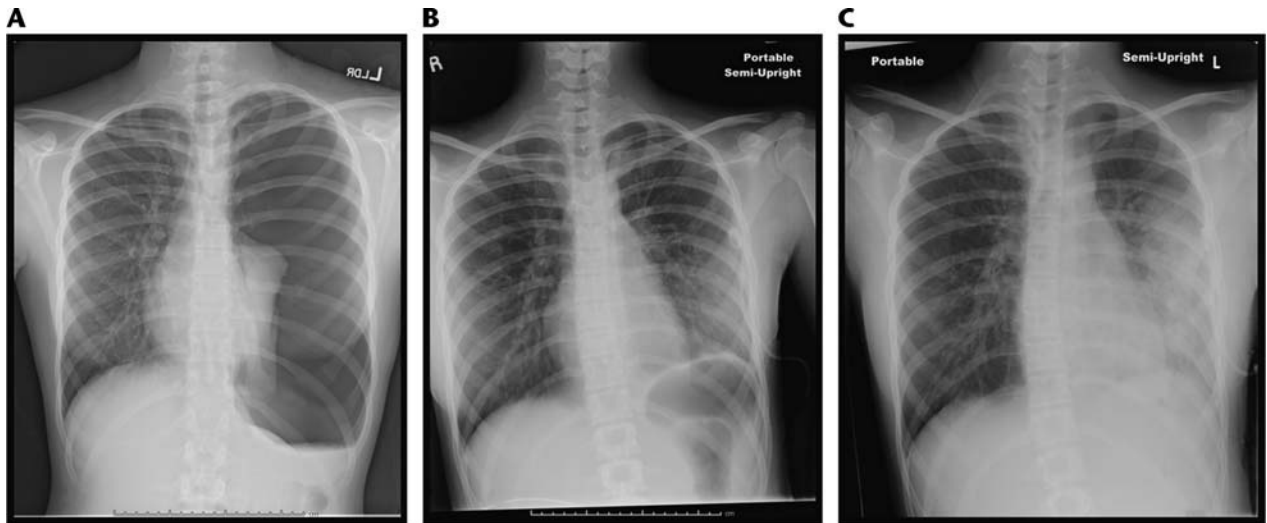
1A, Radiograph of large left side pneumothorax. 1B, Postprocedure film with lung reexpansion after pigtail placement, with residual apical pneumothorax. 1C, Follow-up film with new left-sided reexpansion pulmonary edema.
